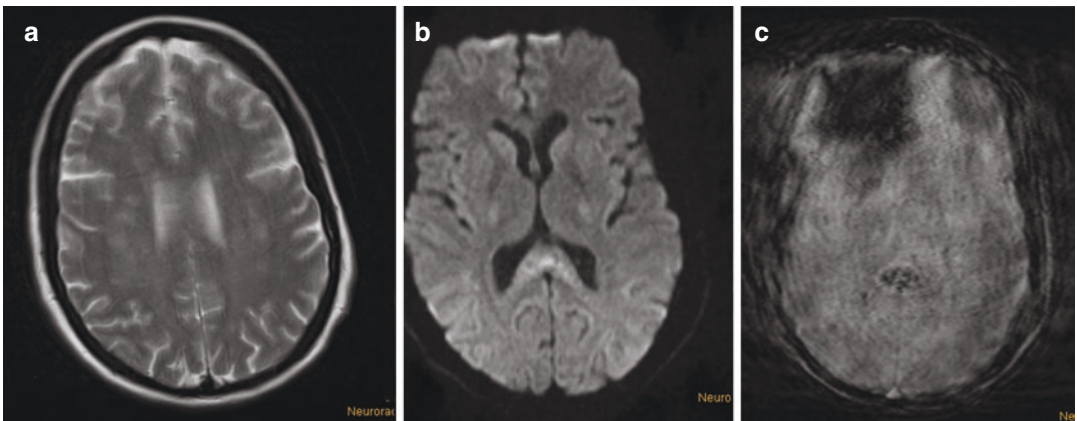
A 30-year-old initially awake polytrauma patient developed progressive vigilance loss after 3 days. MRI after 7 days show patchy and confluent T2 hyperintense
